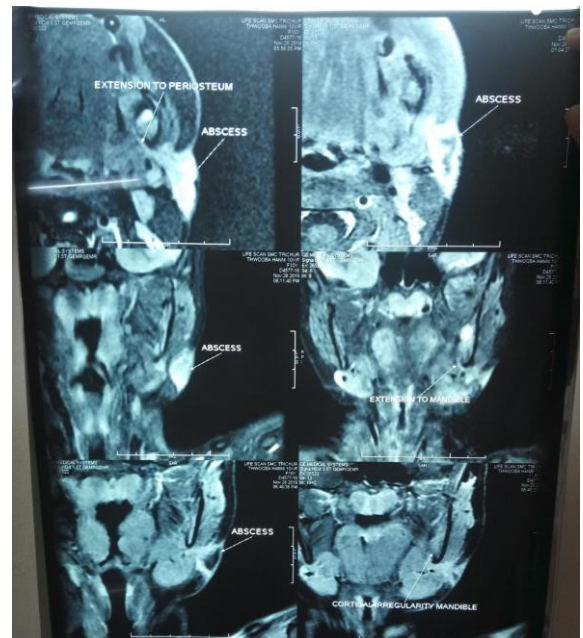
CT showing a well-defined thick walled subcutaneous abscess with minimal cortical bone irregularity in the inner surface of the left angle of mandible. Focal bulge of periosteum was also noted
